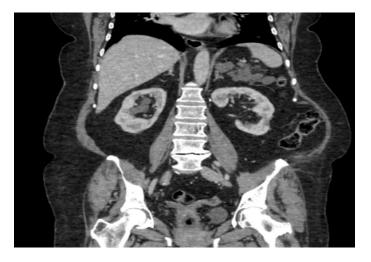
Coronal computed tomography sections: nonenhancing multilobulated cystic lesion in the left adrenal gland.
